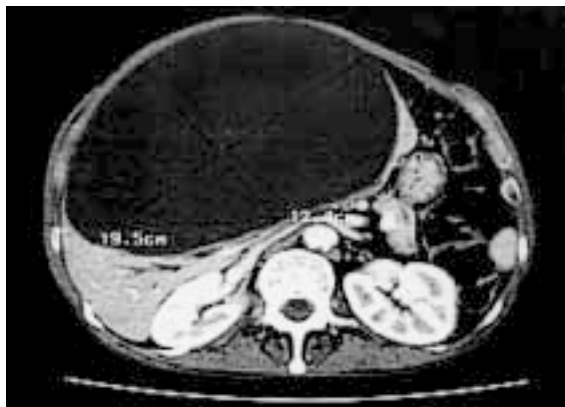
CT scan showing the 19.5 x 12.4 cm simple liver cyst.
